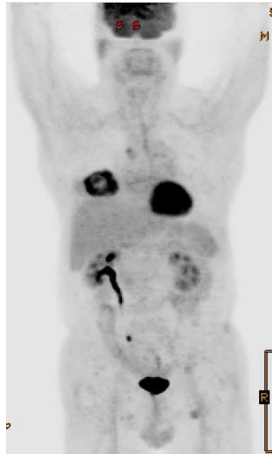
FDG PET scan at the end of radiotherapy combining with hyperthermia and GM-CSF. The image shows excellent response in lung mass of primary site which was irradiated and complete remission in all metastatic lesions which were outside the radiation field
